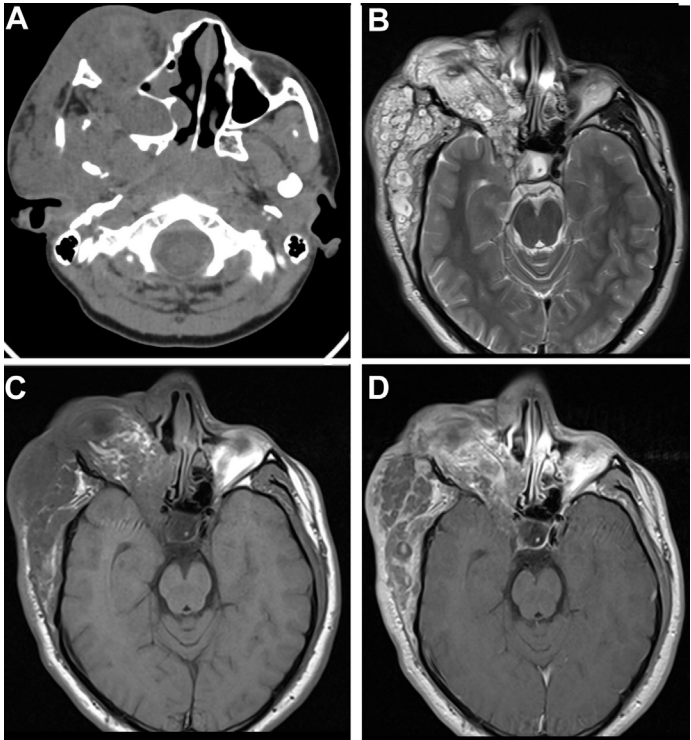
Plexiform neurofibroma in a 17-year-old male patient with NF1. (A) Axial CT scan shows an infiltrative multispacial soft tissue density mass in right side of the face and temporal fossa. (B) Axial T2WI shows multiple target sign within the plexiform neurofibroma. (C) Axial T1WI and (D) postcontrast T1WI show intermediate signal lesion with heterogeneous enhancement.
